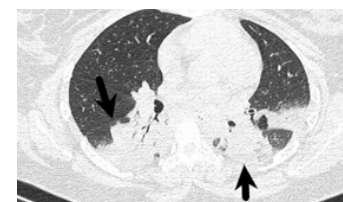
Axial nonenhanced CT lung window showing isolated consolidation (arrow) with air bronchogram in 26 year old female with lower lobe and posterior predilection.
